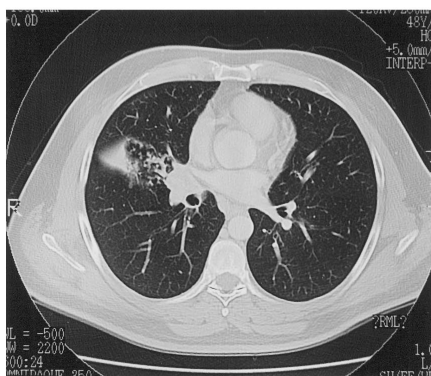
Chest radiograph (top) and CT scan (bottom) demonstrating right middle-lobe infiltrate and possible hilar mass.
